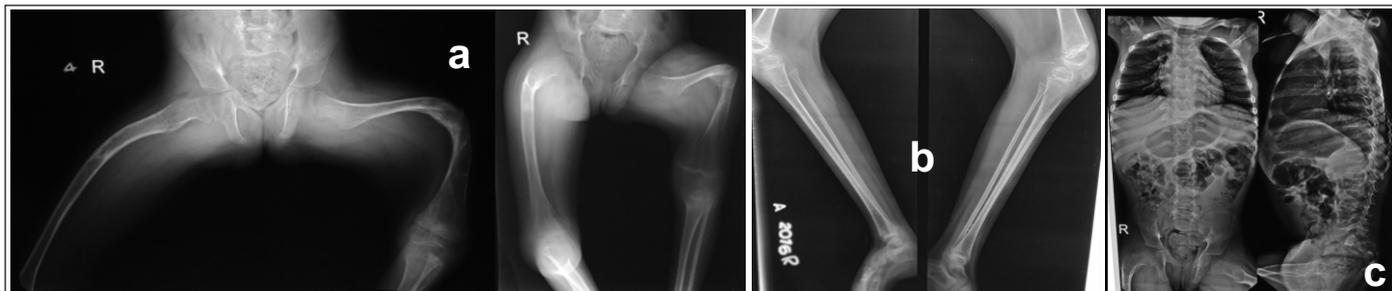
Radiographs at presentation, aged 8.5 years.
